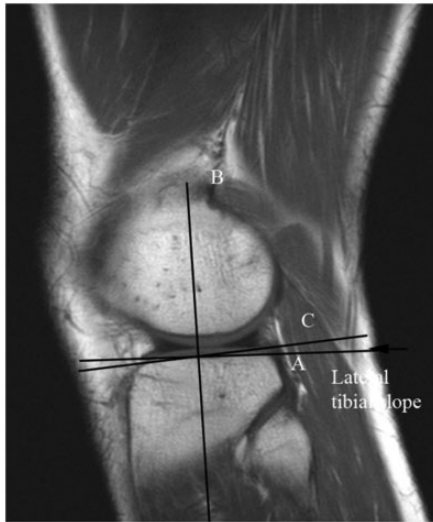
Sagittal T1-weighted image showing LTS measurement [angle formed by the line (line C) perpendicular to the tibial axis (line B) and the line running along the tibial slope of the lateral tibial condyle (line A)]. LTS, lateral tibial slope.
